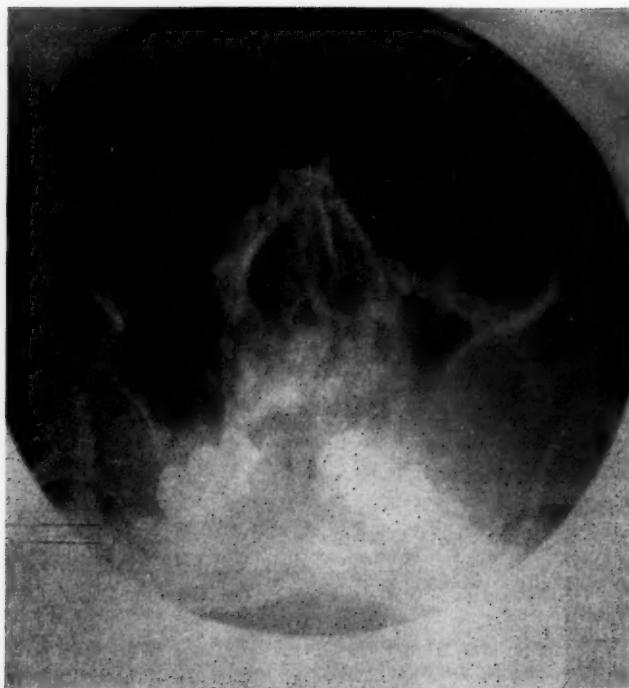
Pre-operative x-ray showing medial displacement of lateral wall right maxillary sinus and soft tissue mass within right cheek.
